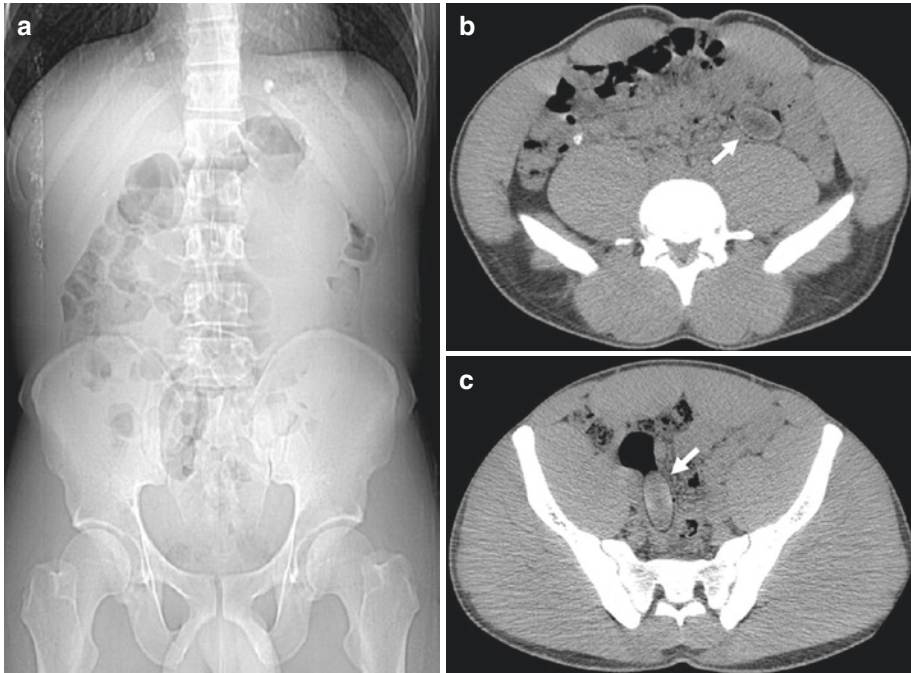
CT examination: scout view (a) and axial scans (b, c). The ingested packets are detected as round or oval dense foreign bodies located within different portions
